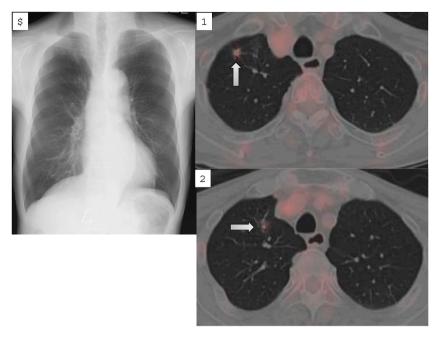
PA chest radiograph was normal on initial presentation (A). Axial CT chest from PET-CT shows two FDG-avid ground glass nodules in the right upper lobe (B,C).
